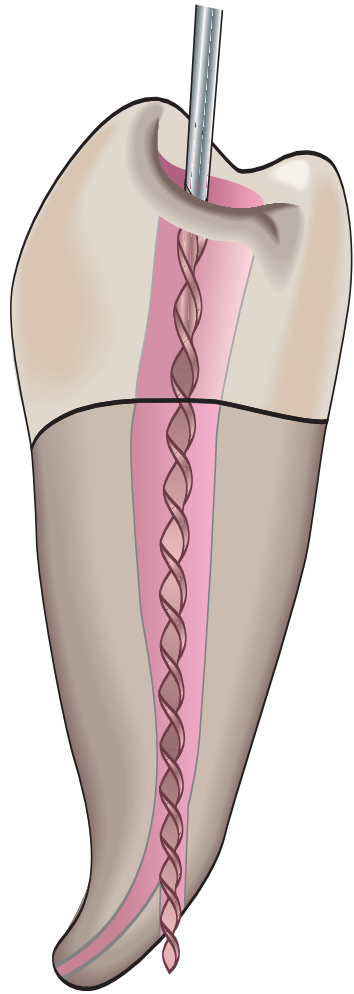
Operative errors—mandibular premolars. Perforation at the apical curvature is caused by a failure to recognize, by exploration, buccal curvature. A standard buccolingual radiograph does not show buccal or lingual curvature. One should also be wary of perforating the apical foramen in perfectly straight canals, a common cause of acute apical periodontitis.
